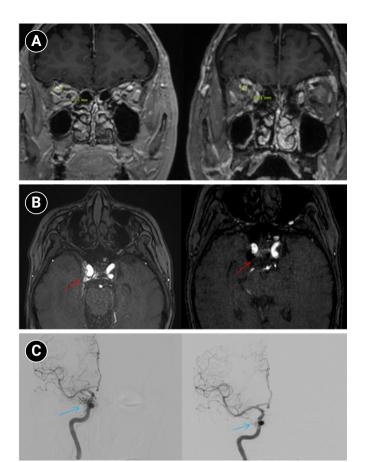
Imaging changes before and after embolization. (A) Brain magnetic resonance imaging (coronal section through the orbits) shows a decrease in the diameter of the right superior ophthalmic vein from 6.63 mm pre-embolization to 4.61 mm post-embolization, indicating reduced venous congestion. (B) Axial time-of-flight magnetic resonance angiography demonstrates that flow-related hyperintensity within the right cavernous sinus is markedly reduced after embolization (red arrows), consistent with decreased shunt flow. (C) Digital subtraction angiography images before embolization show abnormal early pericavernous venous filling along the right cavernous sinus region (blue arrows), compatible with carotid-cavernous shunting. On follow-up, this abnormal filling is no longer visualized, consistent with interval reduction in shunt flow.
